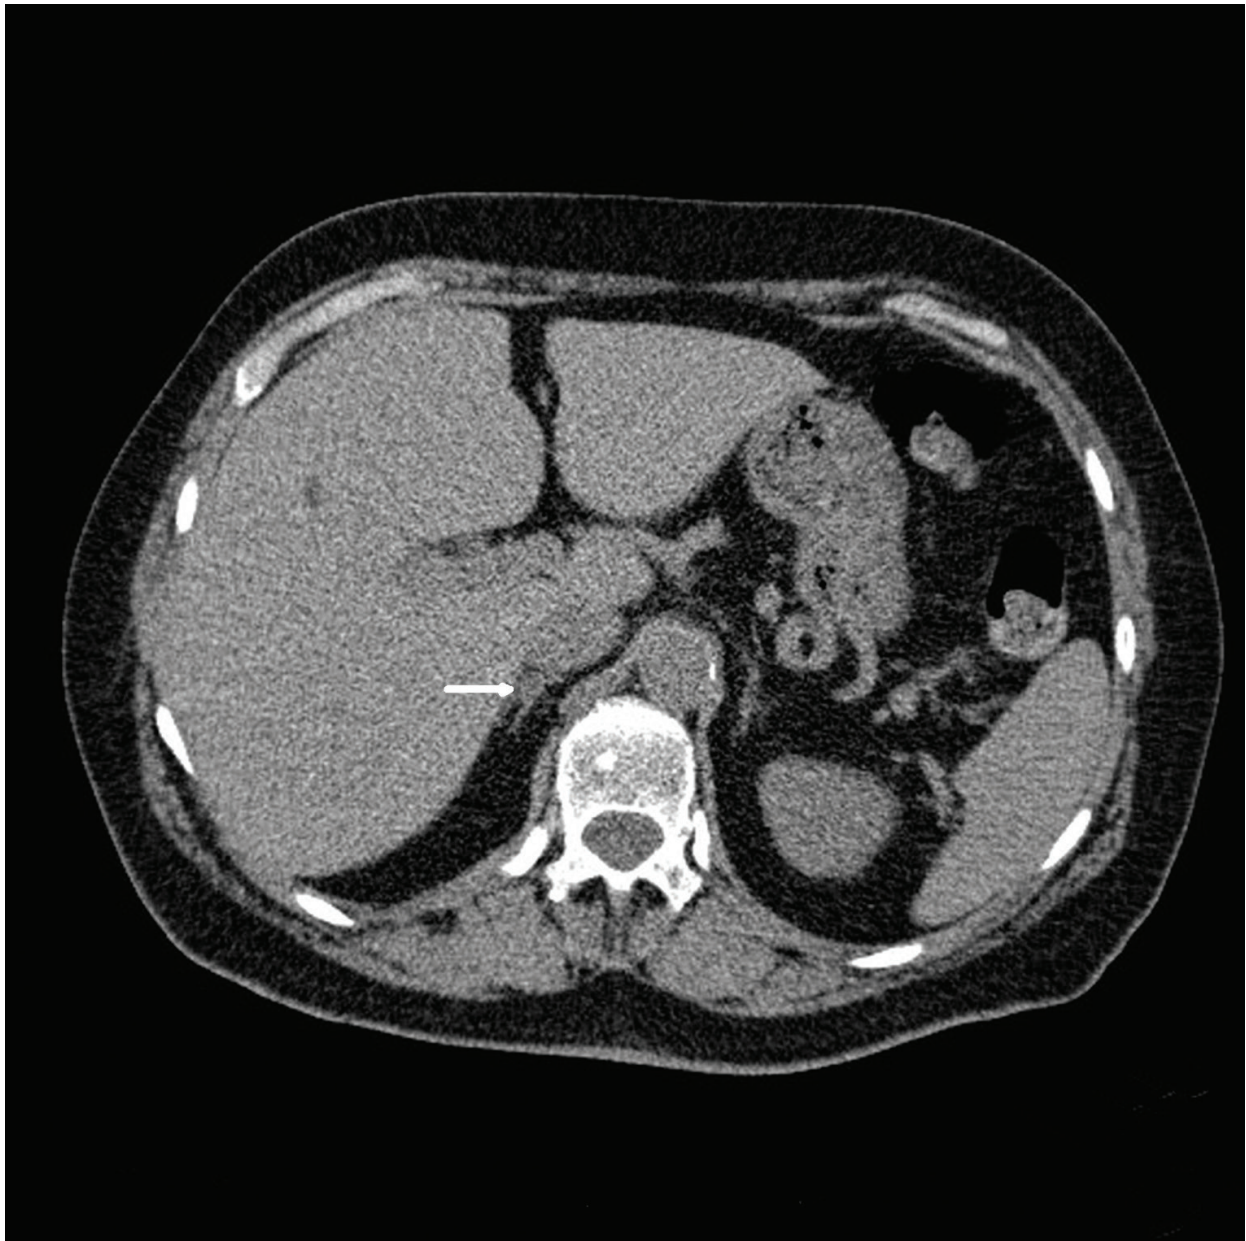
Tiny aldosterone producing adenoma (6 mm) in right adrenal gland (arrow) (CT scan).
